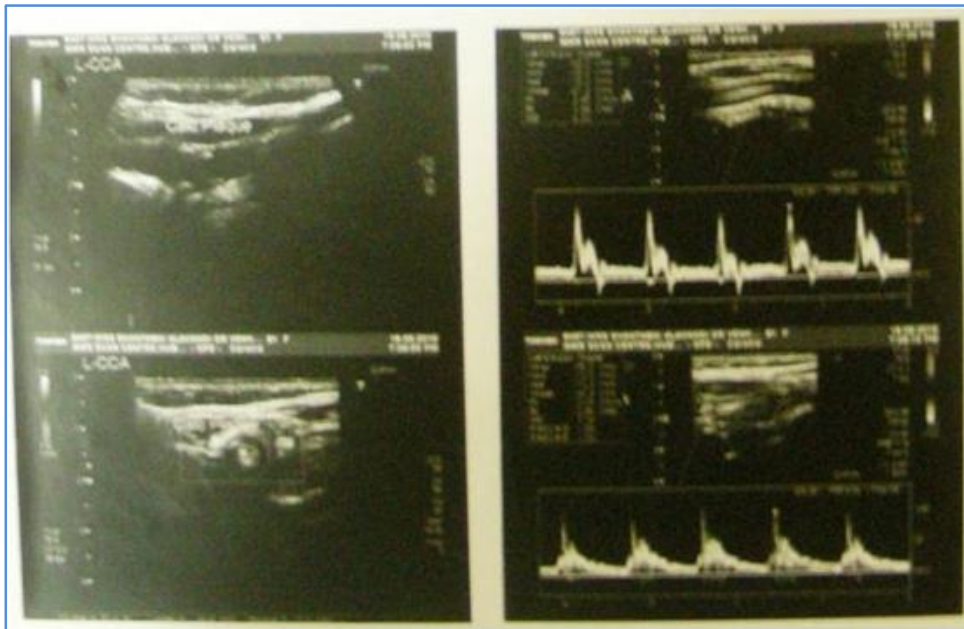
Ultrasonographic image showing calcified plaque at left carotid bifurcation- 70% blockage
